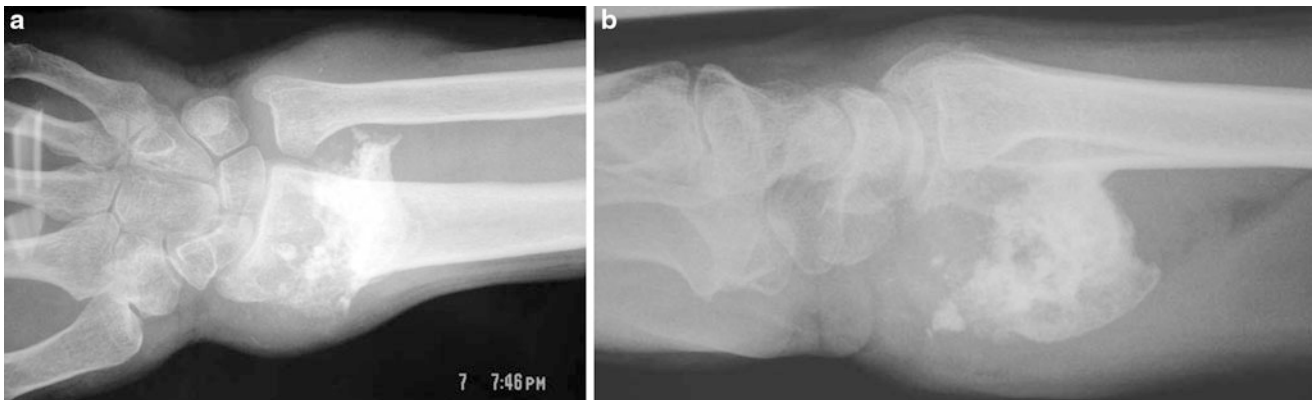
AP (a) and Lat (b) radiographs of the mass, originating from the distal radius, invading the distal radioulnar joint and ulna
